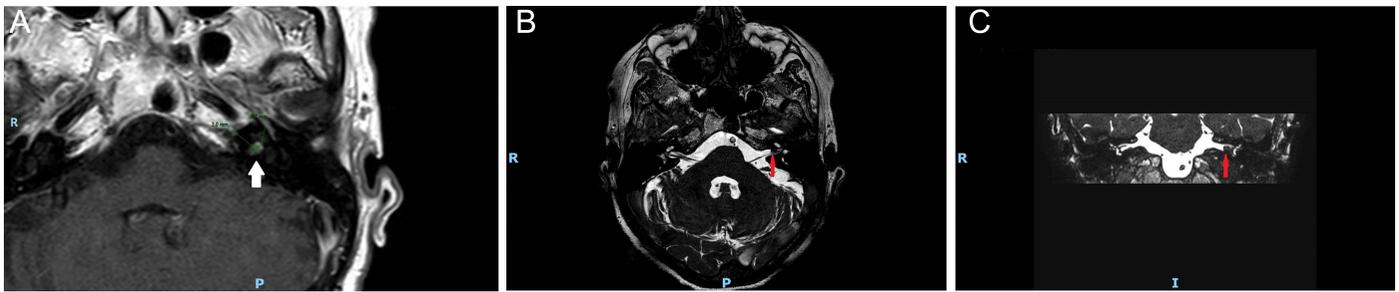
T1- and T2-weighted MRI showing (red yellow in T2 images) a left intracanalicular VS. (A) axial T1; (B) axial T2; (C) coronal T2. MRI, magnetic resonance imaging; VS, vestibular schwannomas.
